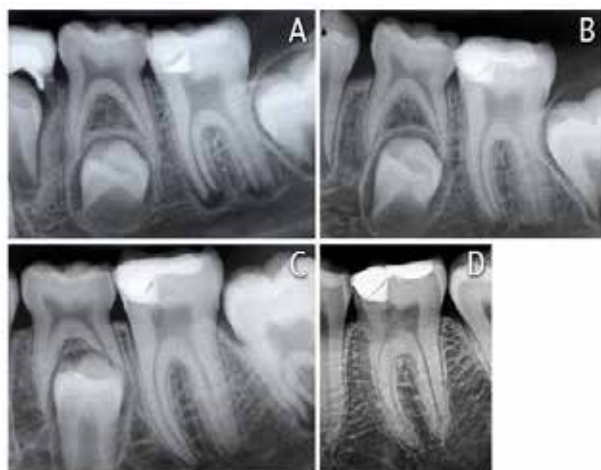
(a) Postoperative periapical radiograph immediately after treatment; (b) Postoperative periapical radiograph taken at the two-year recall visit. Note the continued root development and 0.5 mm dentine bridge that formed at the exposure site; (c) Postoperative periapical radiograph taken at the four-year recall visit. Note the closure of the apices of the mesial and distal roots and an increase in the thickness of the dentine bridge; (d) Postoperative periapical radiograph taken at the 14-year recall visit. The periodontal ligament around the apical third of the mesial root was still widened, and a small calcification or pulp stone formed in the pulp chamber.
